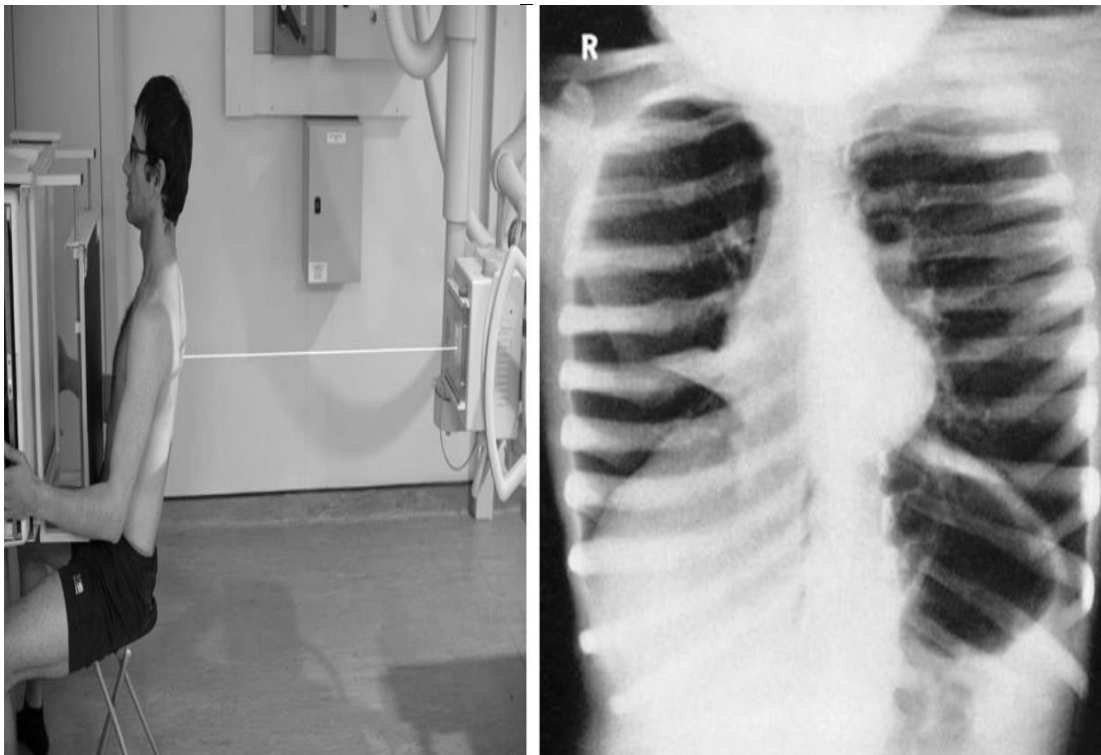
Lordotic posterior-anterior radiograph showing middle lobe collapse
